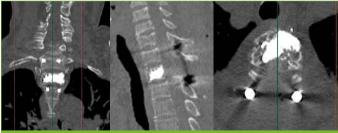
Postoperative CT scan demonstrating the satisfactory cement distribution in the lesion and decompression.
